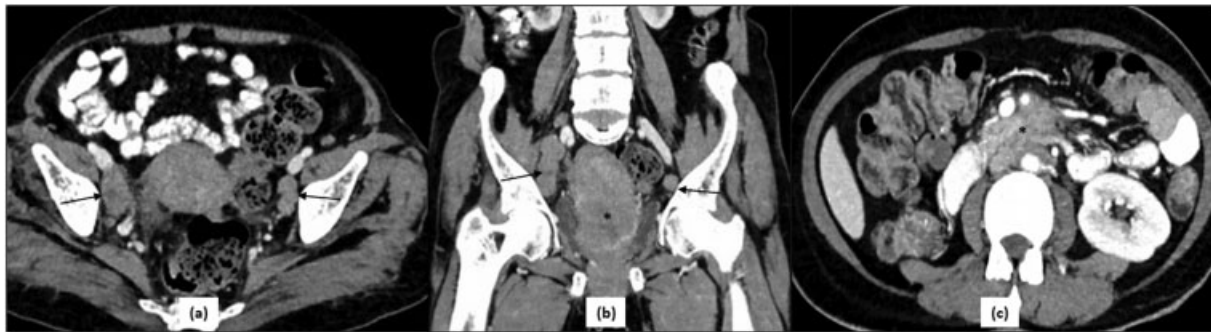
CT in stage IIIC of carcinoma cervix—(a) Axial and (b) coronal reformatted images of a patient with carcinoma cervix reveal a large irregular heterogeneous mass (asterisk in b) replacing the normal cervix and extending into the uterine body. In addition to the primary mass, there are enlarged lymph nodes along bilateral iliac vessels (black arrows) with few showing necrosis within; and conglomerate nodal mass (asterisk) in the preaortic location (c) representing stage IIIC according to 2018 FIGO staging system.
